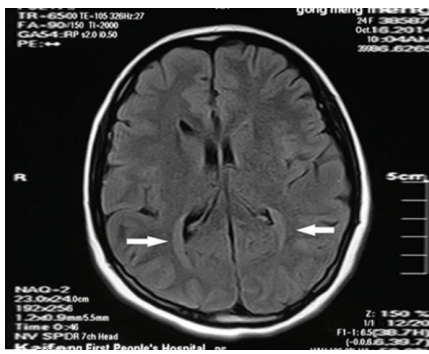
T₂ FLAIR 轴位,双后角后有结节状灰质信号
